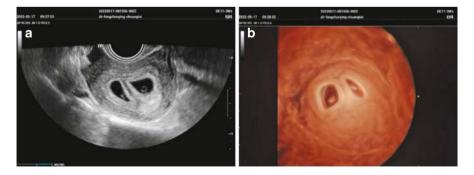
(a) A case of DCDA twin pregnancy, 40 days into natural gestation: two gestational sacs are visible in the uterine cavity, with a yolk sac present in each sac. (b) 3D ultrasound showing two gestational sacs
